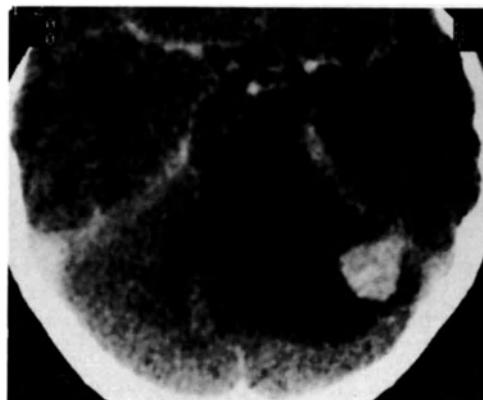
CT shows both the tumor cyst and the vascular hemangioblastoma nodule. Post enhancement scan.
